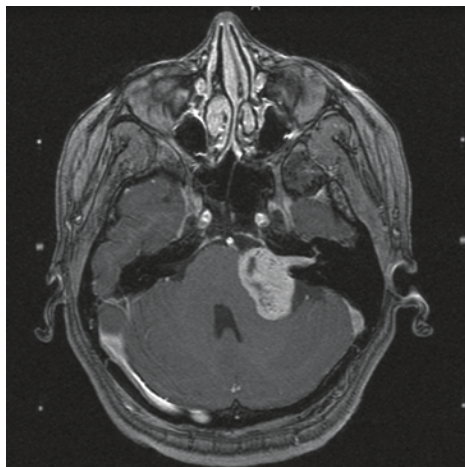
(Left) Axial MRI of VS patient in Leksell head frame on the day of GKS.
